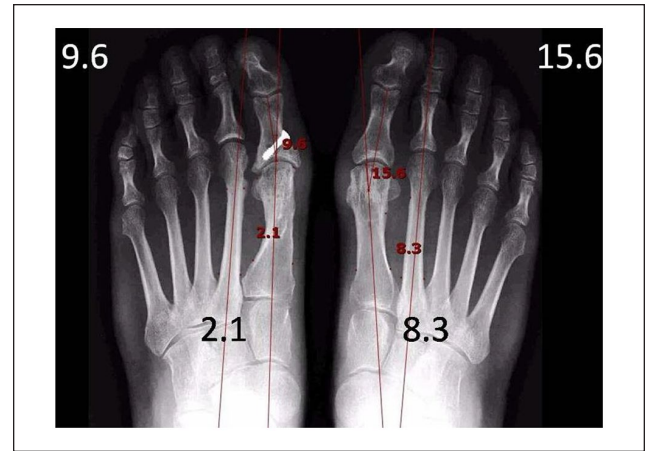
Follow-up radiograph revealed well-corrected and well-maintained IMA at 2.1 and 8.3 degrees, and MPA at 9.6 and 15.6 degrees of her left and right feet, respectively.
